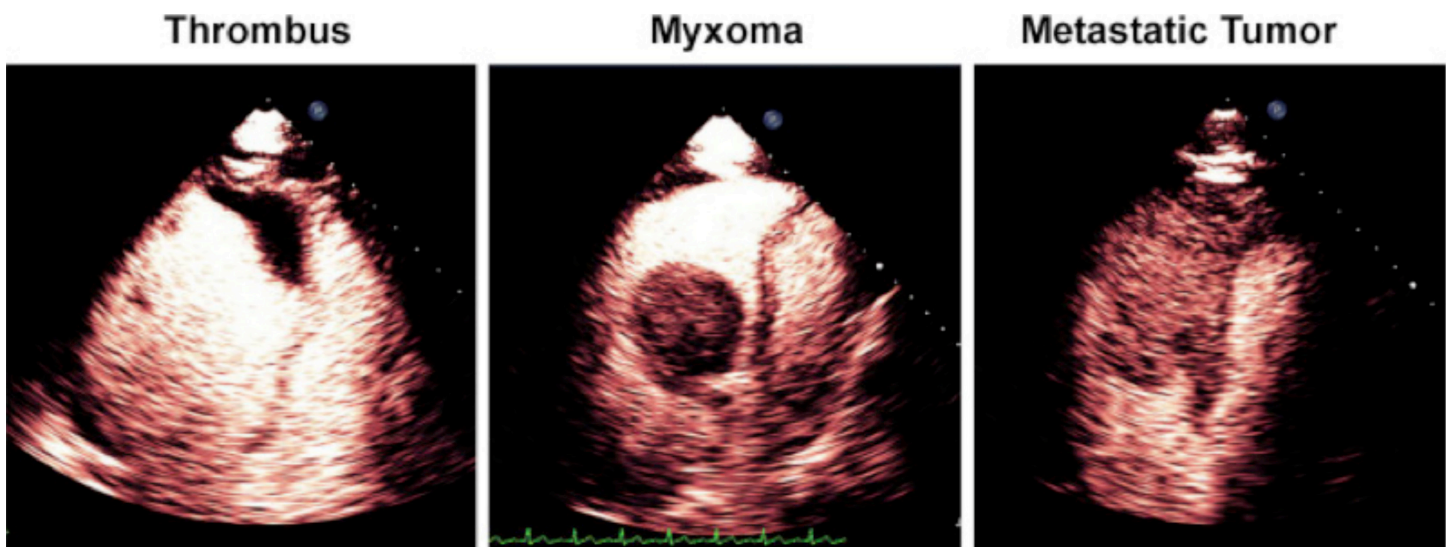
Modified apical four-chamber images of intra-cardiac masses in three separate patients receiving UEAs during transthoracic echocardiography. Reproduced with permission.¹
